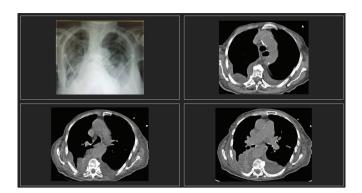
X-ray and computed tomography of the thorax on intensive care unit admission
